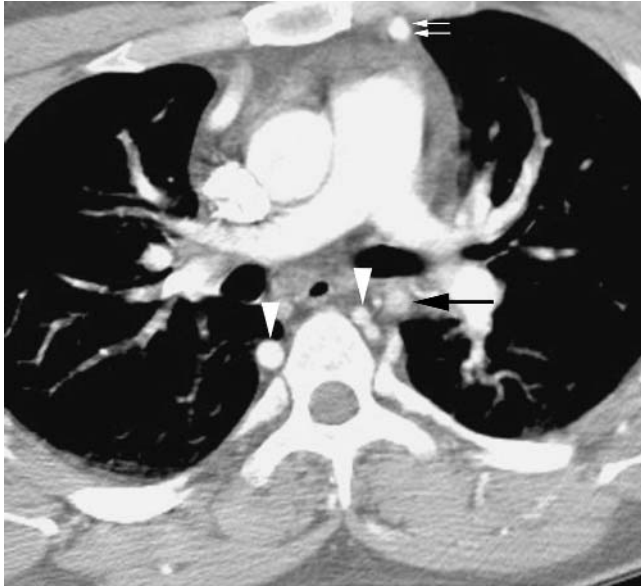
Severe aortic coarctation in a 19-year-old man diagnosed with aortic coarctation using narrow collimation contrast enhanced multislice computed tomography. The axial computed tomography image shows severe aortic coarctation. The main pulmonary artery is seen branching into the right and left pulmonary arteries. The ascending aorta is imaged in cross section alongside the pulmonary artery. In comparison, the black arrow indicates the severely narrowed proximal descending thoracic aorta. Enlarged internal mammary arteries (double white arrows) and numerous enlarged collateral vessels (arrowheads) are also present.
